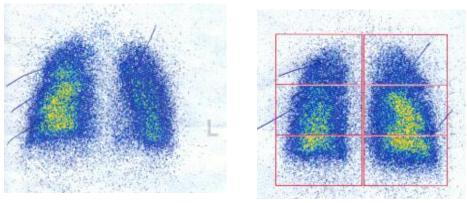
Pulmonary scintigraphy in children with cystic fibrosis. Moderate reduction in pulmonary perfusion of the right lung
